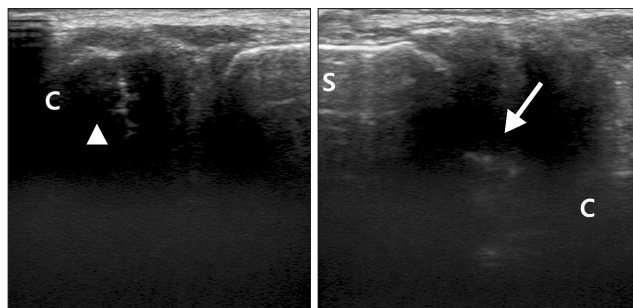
Ultrasound scan of the sternoclavicular joints. Long axis sonographic image of the medial clavicles demonstrates posterior dislocation of the left medial clavicle (arrow), compared with the normally located right medial clavicle (arrowhead). S: sternum, C: clavicle.
